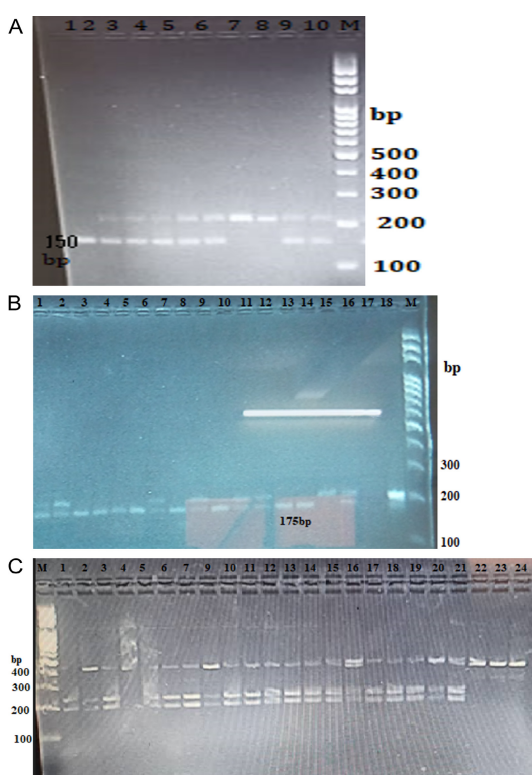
Digestion products for RFLP analysis of study population. A: Digestion products for KCNJ11-rs5219 by BanII enzyme with 2% agarose gel. Lane M: 100 bp ladder, Lane (1): homozygote EE (wild type), Lane (2-6, 9, 10): heterozygote EK (wild/mutant type), Lane (7, 8): homozygote KK (mutant type). B: Digestion products for TCF7L2-rs7903146 by RsaI enzyme with 3% of electrophoresis gel. Lane (1,2,7,9, 10,11,12,16, 18): heterozygote CT (wild/mutant type); Lane (3,4,5,6,8,13,14): homozygote CC (wild type); lane 15: homozygote TT (mutant type); lane 17: negative control. C: Digestion products for rs13266634- SLC30A8 gene by HpaII enzyme with 3% of electrophoresis gel. Lane M: 100 bp ladder; Lane (1): homozygote CC (wild type); Lane (2, 3, 5-21): heterozygote CT (wild type/mutant type); lane (4, 22-24): homozygote TT (mutant type).
